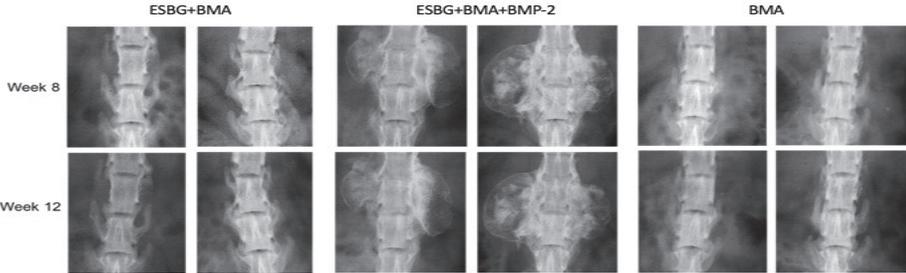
Radiographic evidence of new bone formation at the implantation side at 8 and 12 weeks post-surgery.
